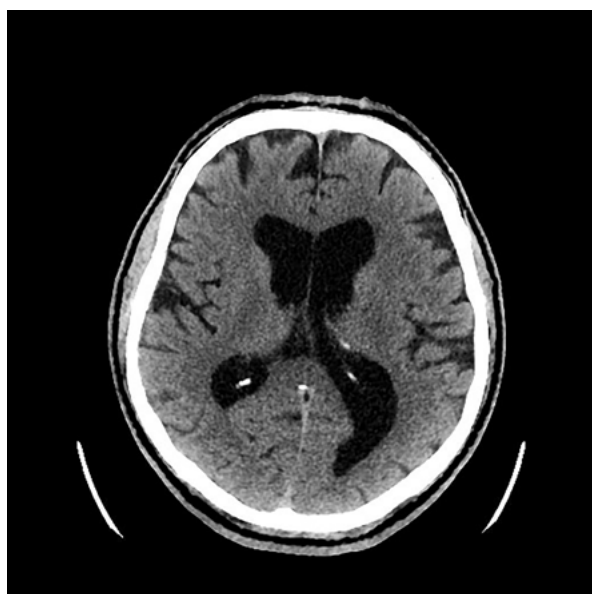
Brain CT performed after the recurrence of aphasia and onset of right-sided paresis revealed no ischaemic lesions
